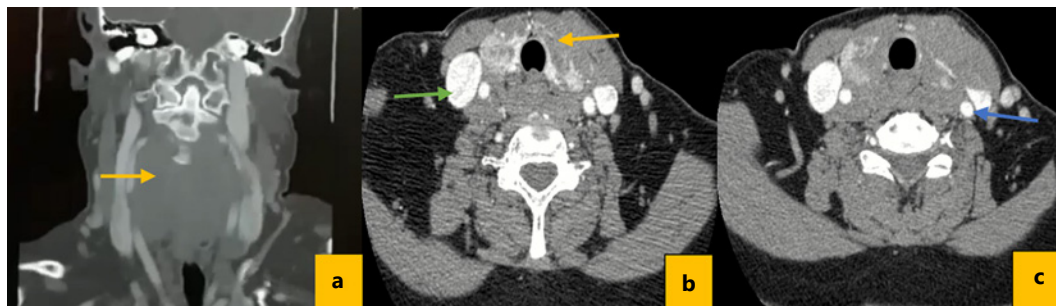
Cervical CT scan with IV contrast. a Multiple heterogeneous thyroid nodules with possible internal necrosis (yellow arrow). b, c Green and blue arrows outline the internal jugular vein and carotid artery, respectively.
